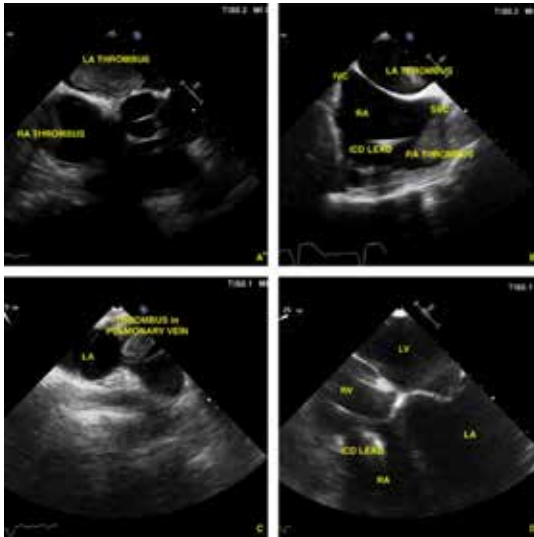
(A-D) Showing left atrial thrombus in transesophageal echocardiography. (B) showing left atrial thrombus and right atrial thrombus hanging from superior vena cava. (C) showing thrombus in pulmonary vein, (D) showing thickened ICD lead due to clot burden.
